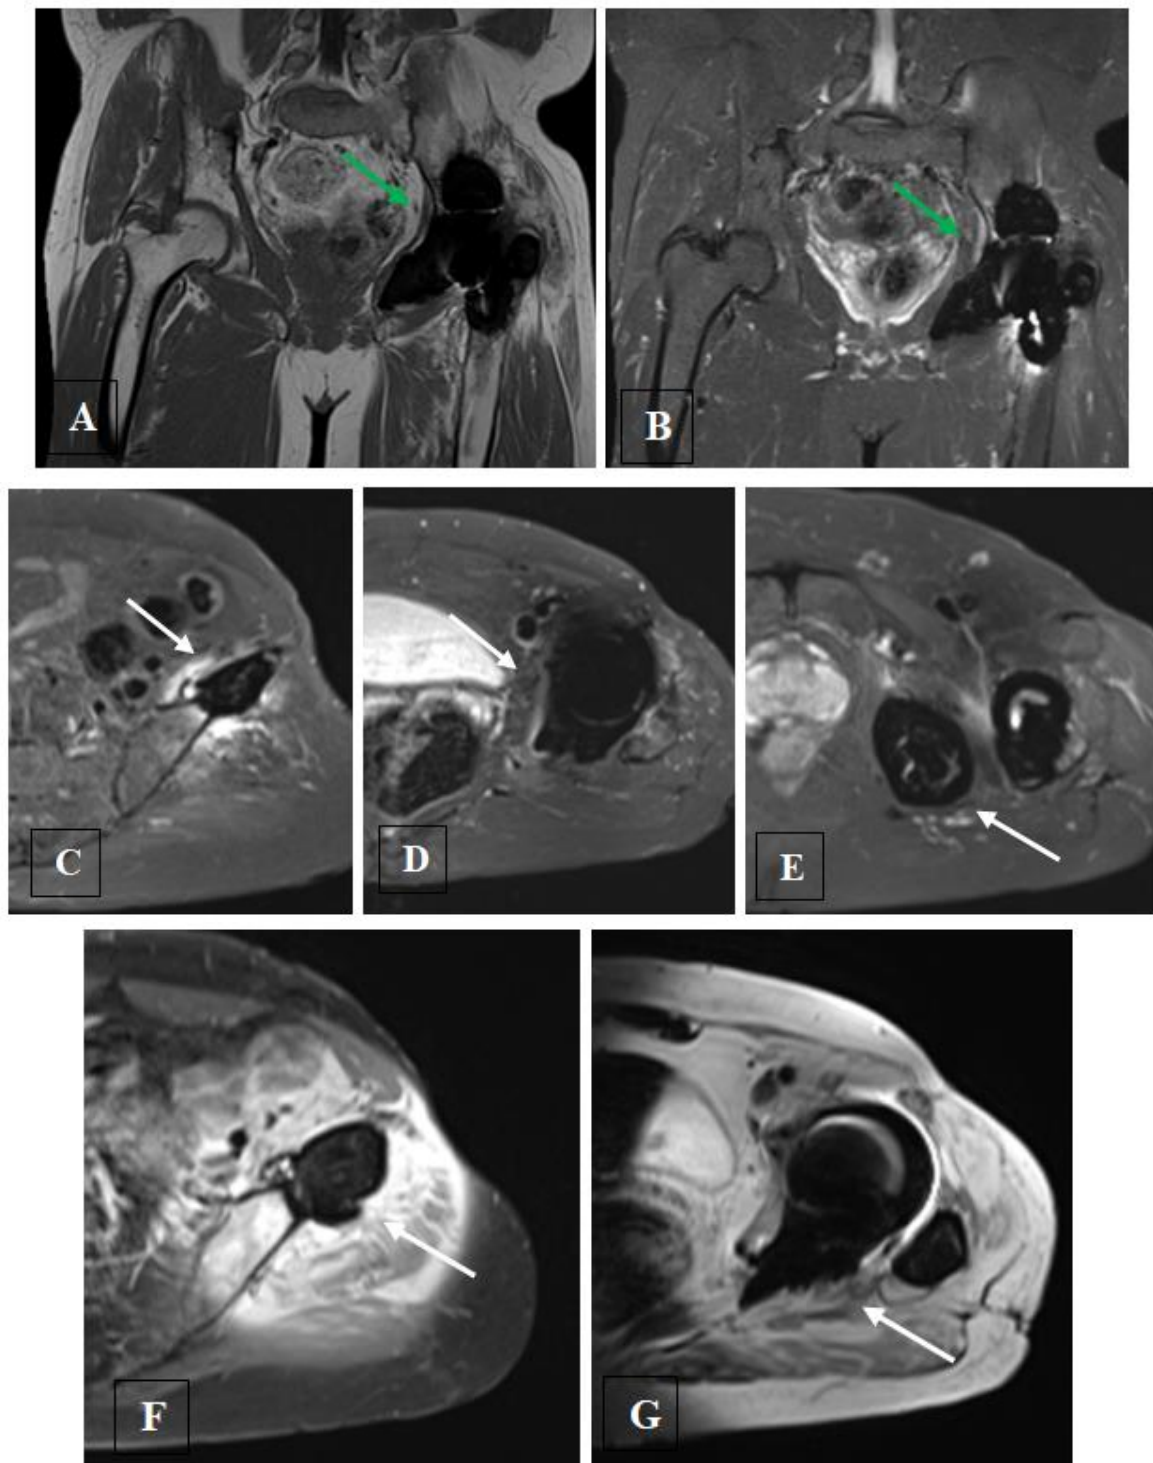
Coronal T1 weighted fast SE (A), coronal (B) and axial (C, D and E) T2W weighted fast SE fat suppressed MR images and axial T1W fat suppressed post-contrast images (F,G) of the left hip arthroplasty system show a low-signal-intensity synovitis with solid appearing pseudotumour (green arrows) located along the capsule of the left hip joint. There is erosion into the left iliac fossa (white arrow in C), the acetabulum (white arrow in D), and the ramus of ischium (white arrow in E) without post-contrast enhancement causing osteolysis with susceptibility artifact from the metal debris and surrounding soft-tissue edema. Artifact from left hip prostheses is also present in the axial T1W fat suppressed post-contrast images.
